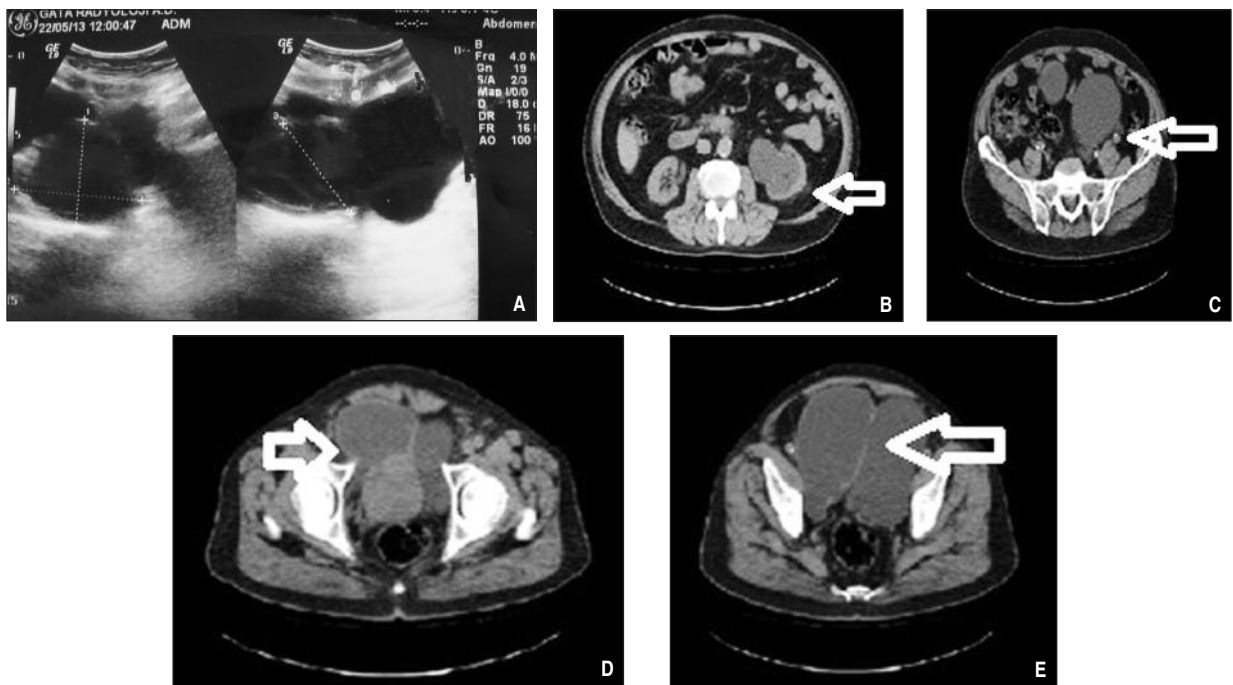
A) Bladder diverticulum on ultrasound; the diverticulum extends behind the bladder and has a wide mouth B) Severe left ureterohydronephrosis, C) Compressing of distal part of the left ureter D) Bladder being pushed at the right side of the pelvic cavity E) Diverticular neck.
